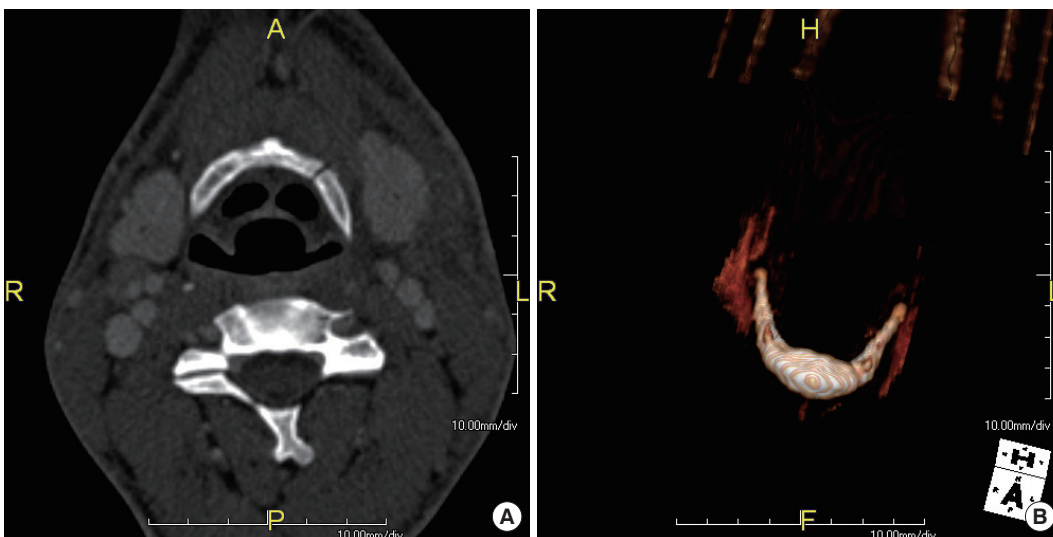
(A) A cervical computed tomography (CT) scan showed a slightly displaced fracture of the hyoid bone between the left greater horn and the body. (B) A three dimensional CT scan of the hyoid bone.
